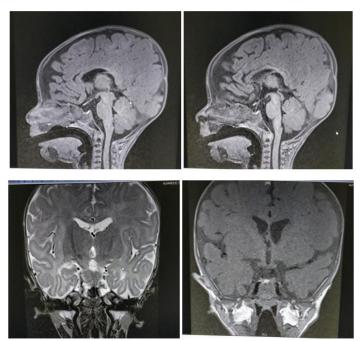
An MRI of the pituitary and hypothalamic region showed normal study
